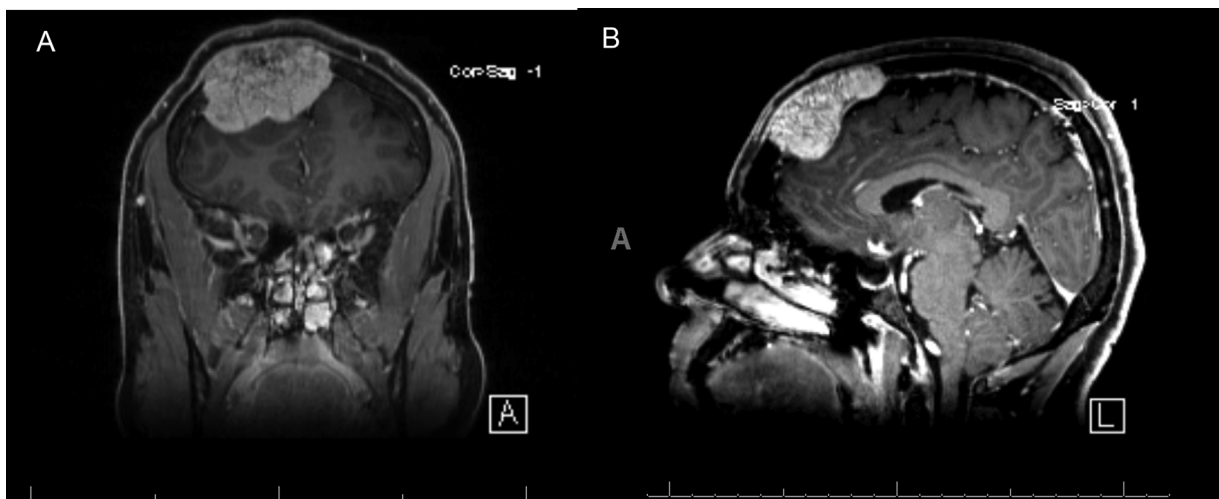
Preoperative T1-weighted postcontrast magnetic resonance imaging demonstrating large heterogeneously enhancing extra-axial lesion with mass effect on the underlying brain parenchyma. Representative coronal (A) and sagittal images (B).
